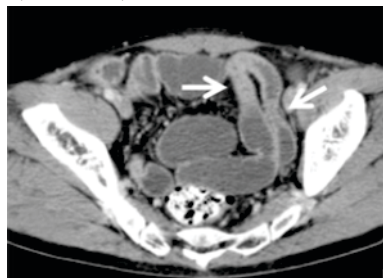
Axial CT image shows isolated short and long-segment ileal strictures (arrows)
